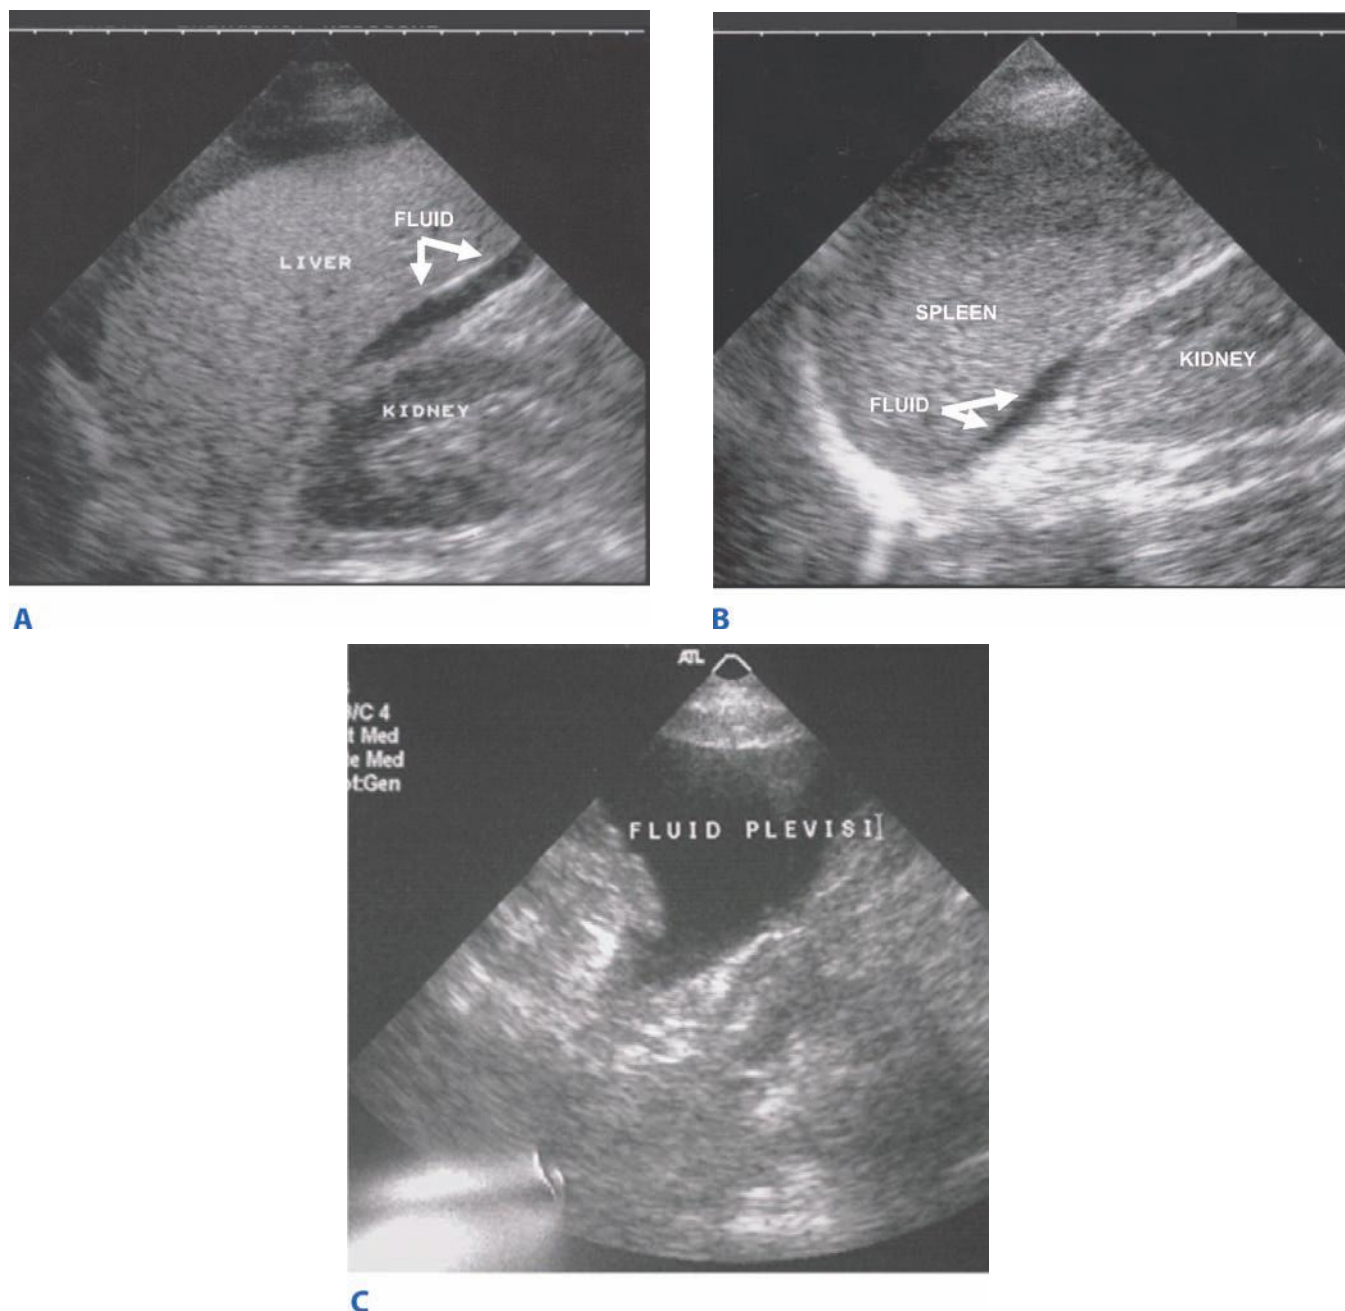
Focused abdominal sonography for trauma imaging detects intra-abdominal hemorrhage. Hemorrhage is presumed when a fluid stripe is visible between the right kidney and liver (A), between the left kidney and spleen (B), or in the pelvis (C).
